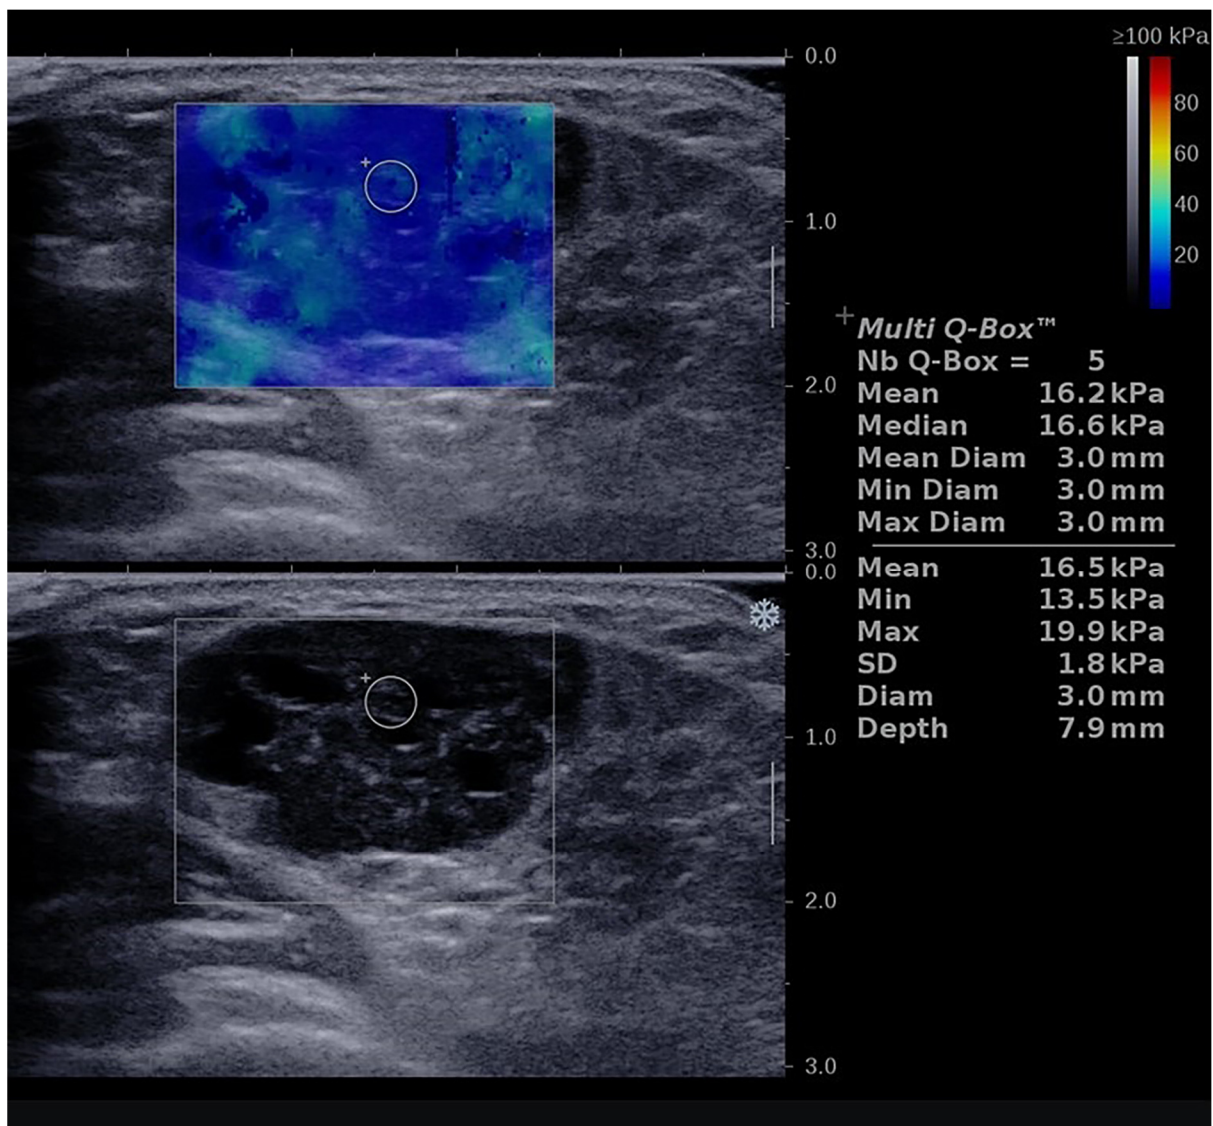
Shear wave elastography (top) and corresponding grey scale ultrasound image (bottom) of the parotid gland showing a hypoechoic, heterogeneous tumor mass. The image displays the mean and median values after 5 consecutive measurements taken at the site of the tumor mass, indicating increased stiffness in a patient with primary Sjögren's syndrome complicated by parotid non-Hodgkin lymphoma.
